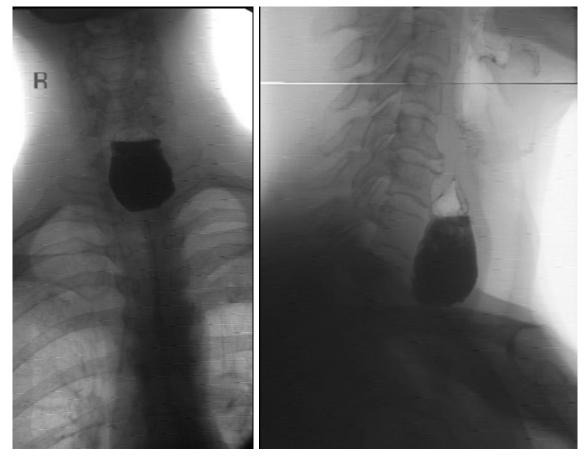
Frontal and lateral roentgenograms. Zenker's diverticulum with symptoms of diverticulitis.
